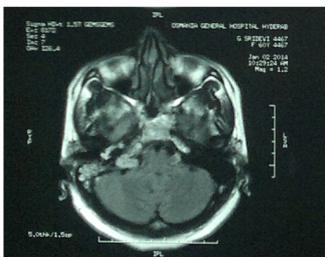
MRI Brain shows hypointense lesion in CPangle cistem on right side, Glomus Juqulare Tumour.
